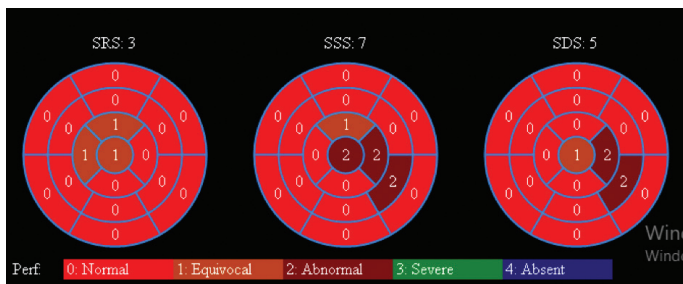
Apicolateral ischemia in myocardial perfusion scintigraphy in 17-zone chart.
